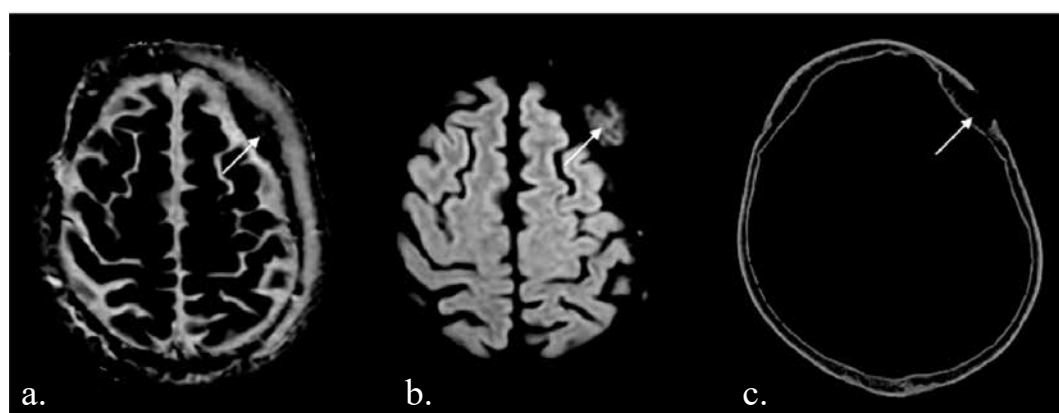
Osteolytic lesion of the frontal bone on the left side (white arrow) 2a and 2b MRI ADC maps and DWI images showing restriction of extracellular water particles with infiltration and edema of the subcutaneous tissue 2c. CT osteolytic lesion destroying the external plate of the frontal bone.
